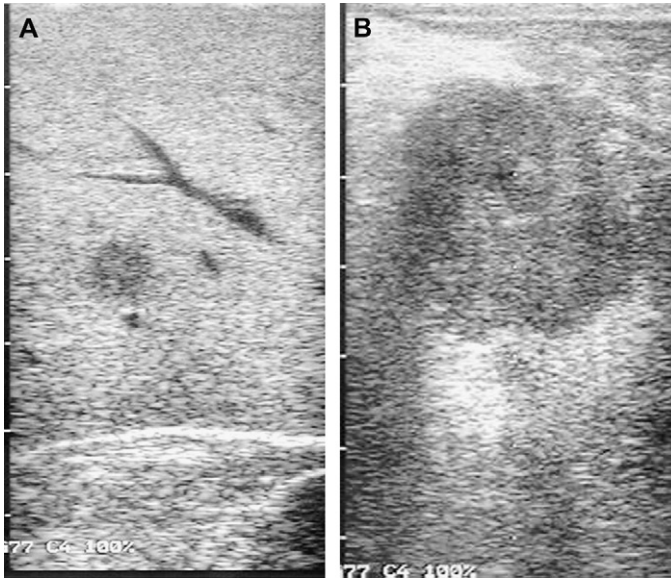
(A) Laparoscopic ultrasound of the liver identifying small liver metastasis. (B) Laparoscopic ultrasound evaluation of pancreatic cancer.
